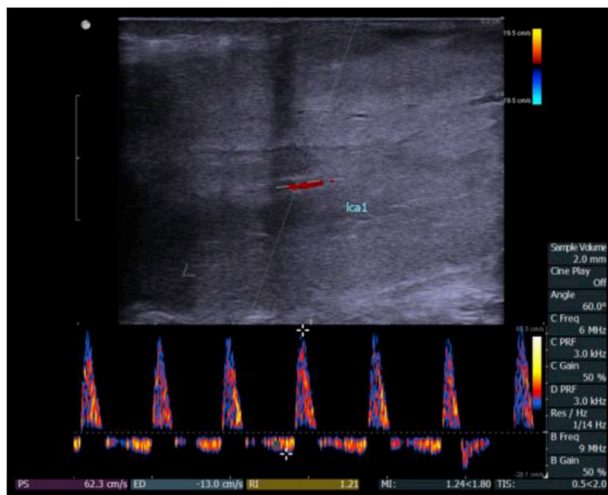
Penile ultrasound measurement of an in-plane cavernosal artery. PSV is 62.3 cm/s, the ED is -13.0 cm/s, and the RI is 1.21.
